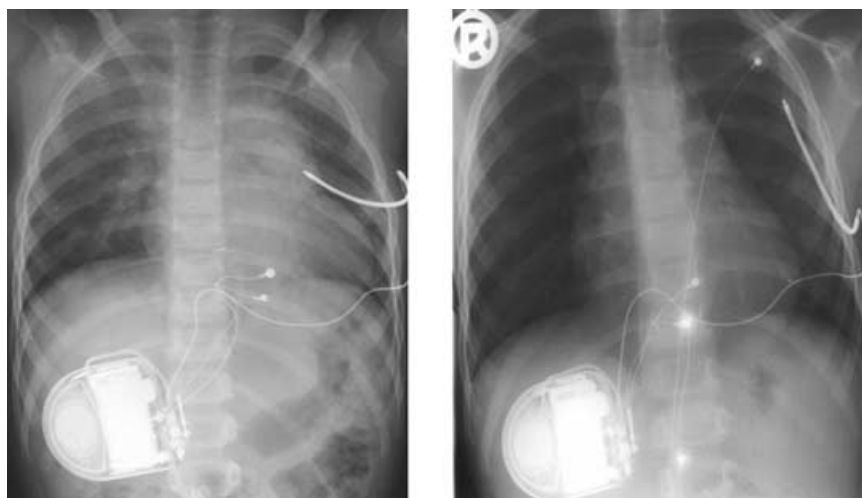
Chest x-ray (left panel: posterior-anterior projection; right panel: lateral projection) of a 6-year-old girl (patient 7; Table I) demonstrating the extracardiac technique. The ICD was placed abdominally, the subcutaneous defibrillation lead is positioned posteriorly along the left chest wall in a subscapular fashion, and the epicardial bipolar sensing and pacing leads are connected on the right ventricle.
